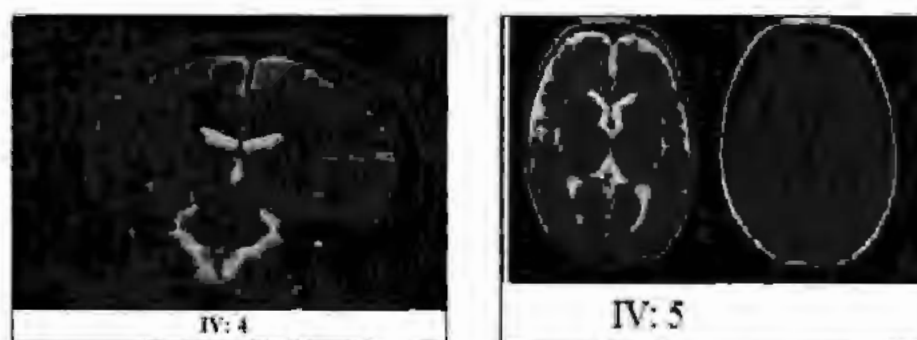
Brain MRI Scan of (IV: 4) demonstrated abnormal deep white mater signal and brain MRI of (IV: 5) demonstrated cerebellar emotional changes with reduced periventricular deep white matter.
